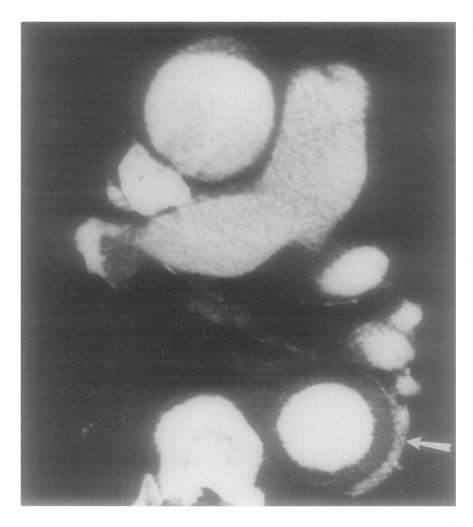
Admission CT image of patient #8 demonstrates IMH of mid-descending thoracic aorta (*arrow*) associated with aneurysmal dilatation of aorta (5.0 cm diameter).
